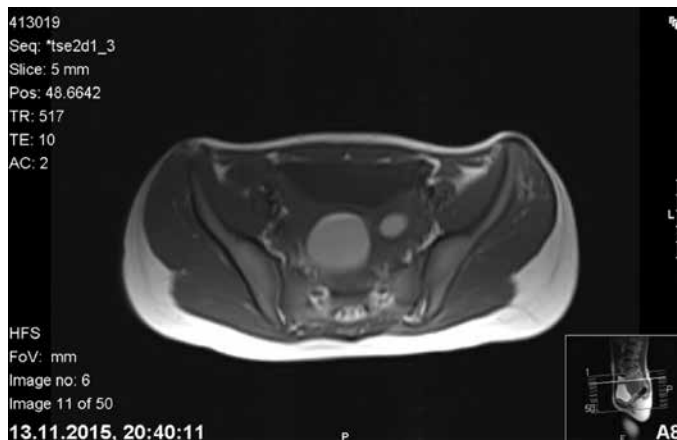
Magnetic resonance image demonstrating uterus didelphys with left hematometocolpos
